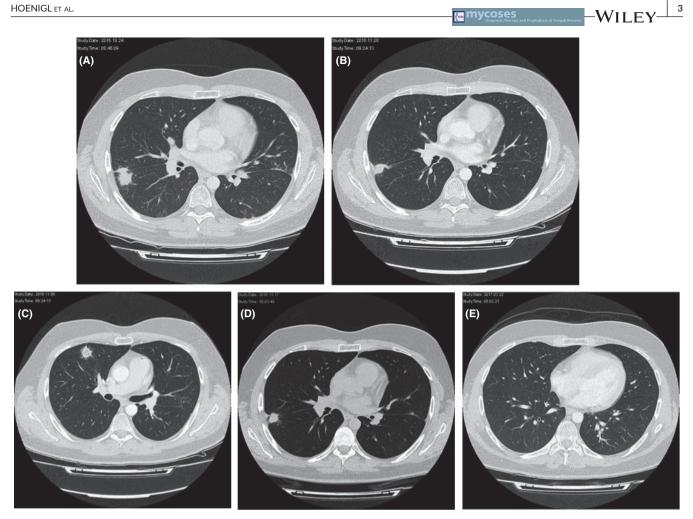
CT scan results (A) During admission 2, before initiation of moxifloxacin, meropenem and vancomycin, showing three subpleural nodules up to 28 mm in diameter and multiple subpleural nodules up to 6 mm diameter, compatible with suspected atypical fungal pneumonia (B and C) During admission 2, sixteen days after antimould therapy was started, showing smaller subpleural nodules (up to 16 mm), one with central cavitation (C). Pleural thickening was seen next to the nodule in the middle/lower lobe (B). (D) Nine days later there was no significant change. (E) Five months after the initial CT scan showing clear improvement
